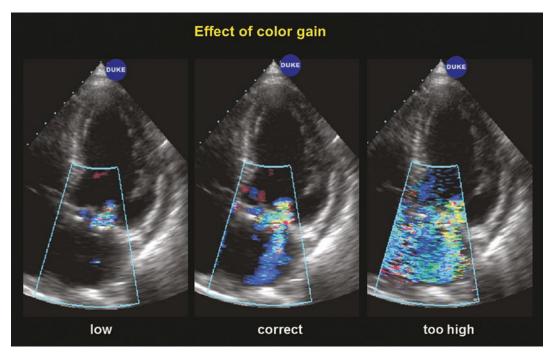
Three panels from the apical four-chamber view in a subject with trivial mitral regurgitation where there is low, correct and excessively high color gain. The
